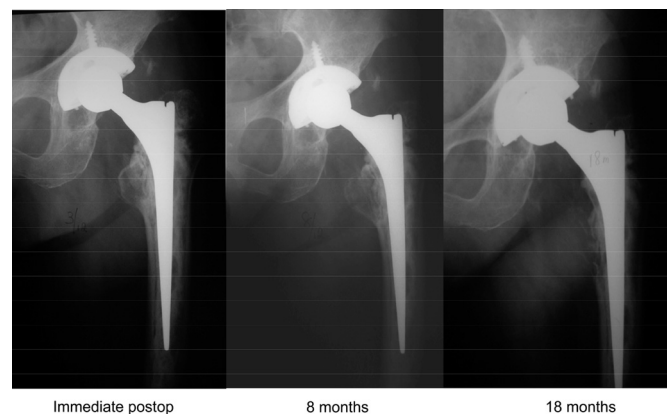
Serial radiographs of revision left THA. Progressive lytic lesion over the lesser trochanter was observed as early as 8 months postoperation. Full thickness erosion of the entire lesser trochanter without periosteal reaction was noted at 18 months. THA = total hip arthroplasty.
